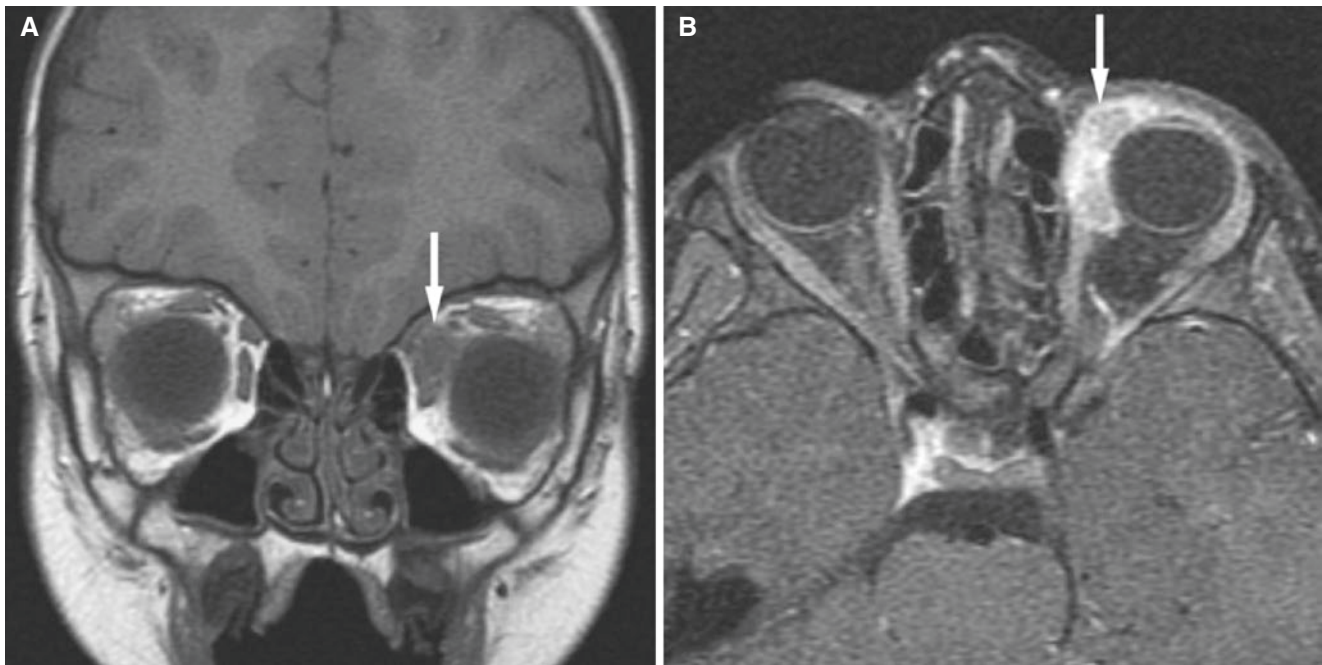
Orbital rhabdomyosarcoma; 4-year-old male with history of left eyelid swelling for one week and low-grade fever. (A) Coronal T1-weighted MRI shows a well-defined mass, isointense to extraocular
